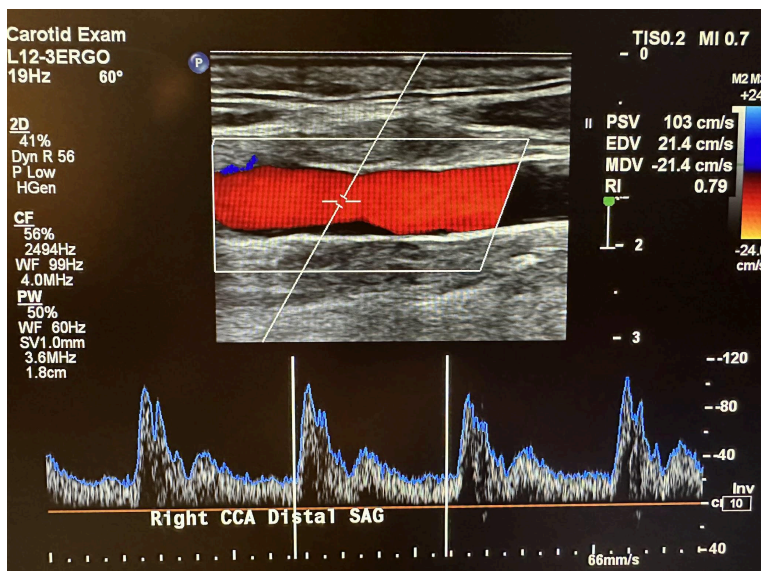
Pulsed wave Doppler with spectral analysis of the common carotid artery in the distal sagittal plane.
